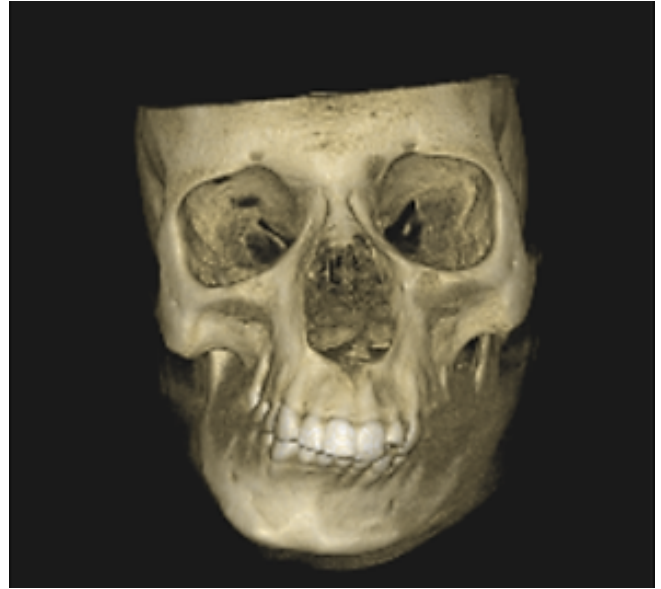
3D CBCT view showing facial asymmetry over right side of jaw region
